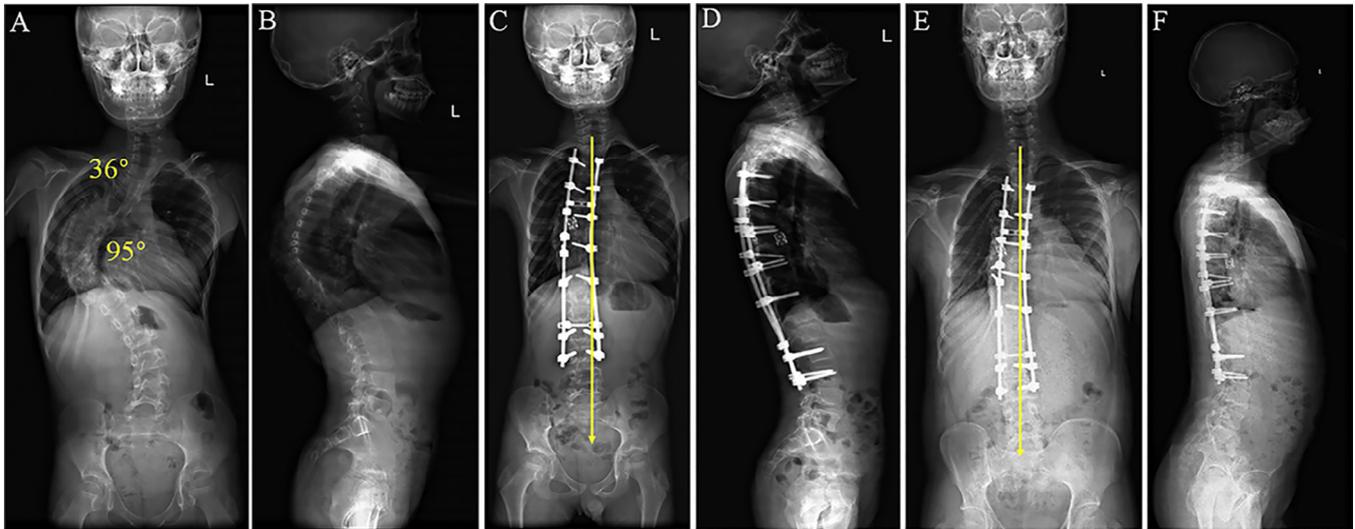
A 15-year-old boy with a severe and rigid thoracic idiopathic curve (A, B). The radiographs demonstrate a thoracic curve of 95° and a cranial curve of 36°. Postoperative posteroanterior (C) and lateral (D) radiographs following posterior spinal fusion from T2 to L3 demonstrate excellent correction of the curves with postoperative values of 25°. Radiographs made 6 years after surgery (E, F) revealed well-maintained global coronal and sagittal balance.
